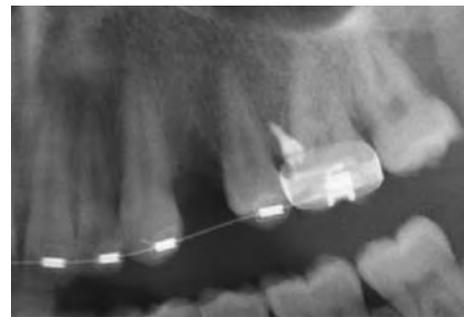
X-ray check after insertion with sufficient bone retention.
